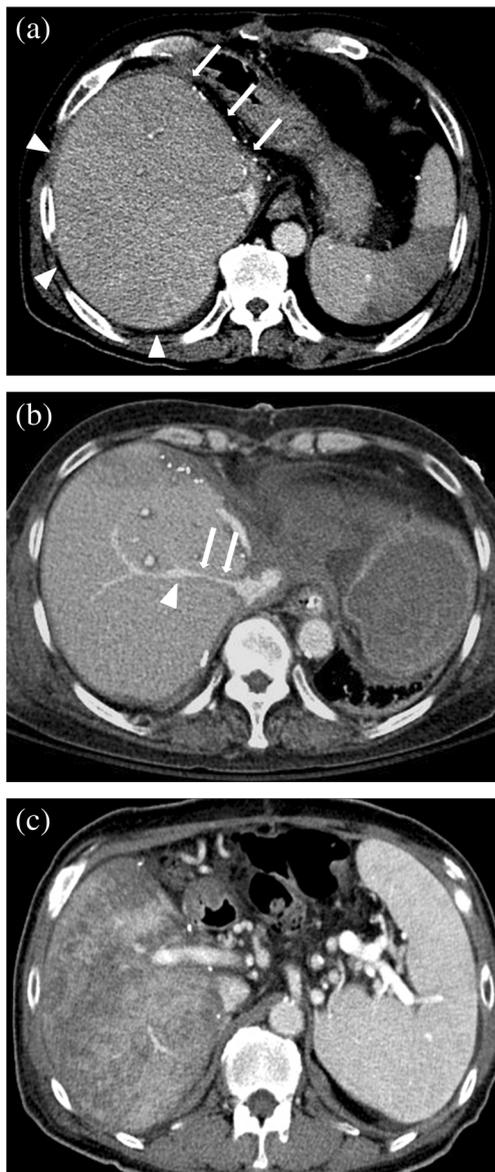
Examples of computed tomography findings associated with acute cellular rejection. a A 59-year-old man underwent right lobe living donor liver transplantation (LDLT) for chronic hepatitis C. A portal venous-phase computed tomography (CT) axial image performed 35 days after liver transplantation (LT) showed severe globular swelling of the graft presenting obtuse angles between any sets of the graft margins including a resection margin (arrows) and free margins (arrowheads). Initial rejection activity index (RAI) was 9. b A 56-year-old woman underwent right lobe LDLT for alcoholic liver cirrhosis. A portal venous-phase CT axial image performed 4 days after LT showed short segmental nonanastomotic luminal narrowing of the right hepatic vein (arrows) with prestenotic dilatation (arrowhead). Initial RAI was 6. c A 65-year-old man underwent right lobe LDLT for alcoholic liver cirrhosis. A portal venous-phase CT axial image performed 72 days after LT showed diffuse heterogeneous enhancement and severe globular swelling of the graft. Initial RAI was 5
